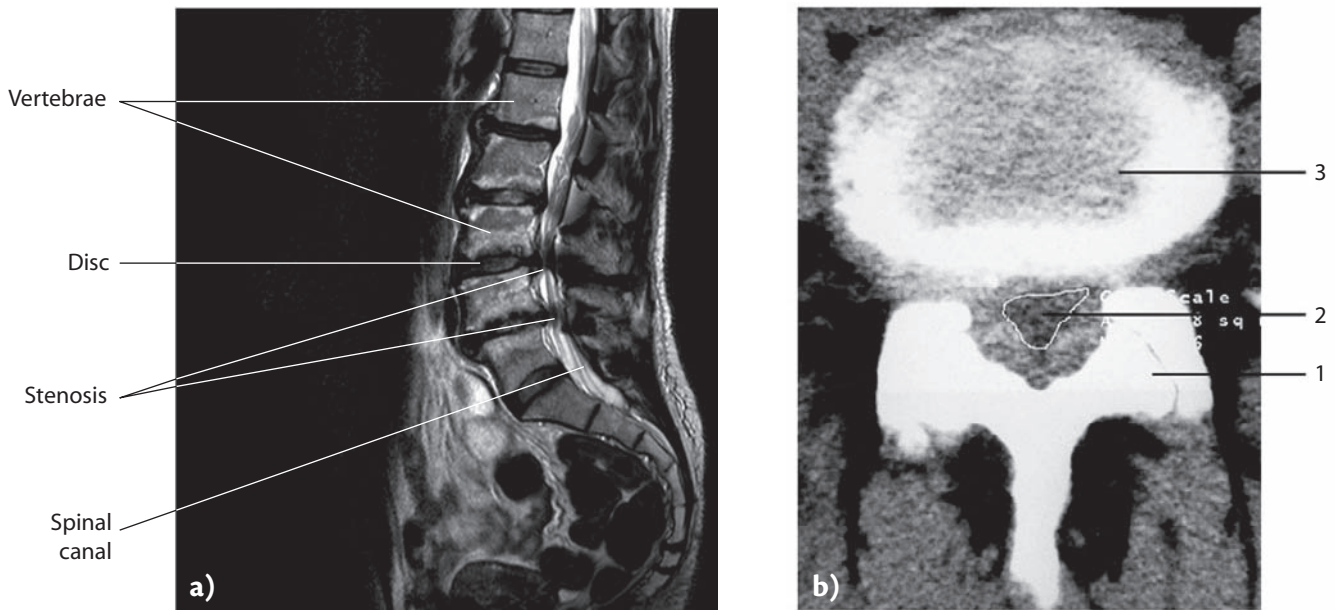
Spinal stenosis of the lumbar spine. a) Magnetic resonance imaging (MRI) of a lumbar spine from the side displays the stenosis of the spinal canal at several levels; b) computed tomography (CT) of the lumbar spine showing the narrowing of the spinal canal. 1: Vertebral arch; 2: remaining space in the spinal canal; 3: disc.
